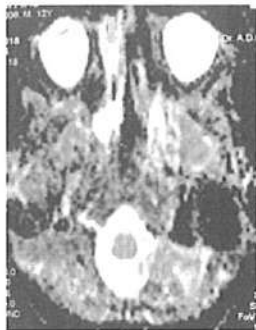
Findings of MRI cisternogram showed CSF leakage into right nostril
